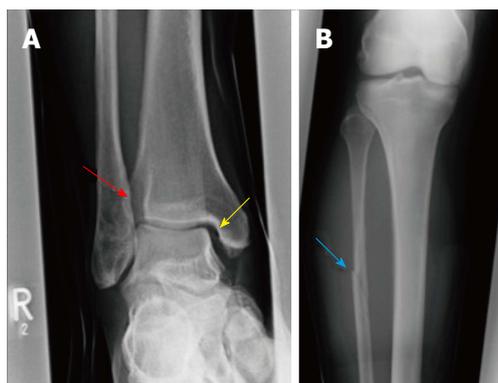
The increased tibiofibular clear space (red arrow) and medial clear space (yellow arrow) are highly suspicious for a syndesmotic lesion (A) and the radiograph of the proximal part of the lower leg is showing a Maisonneuve injury (blue arrow) (B).
